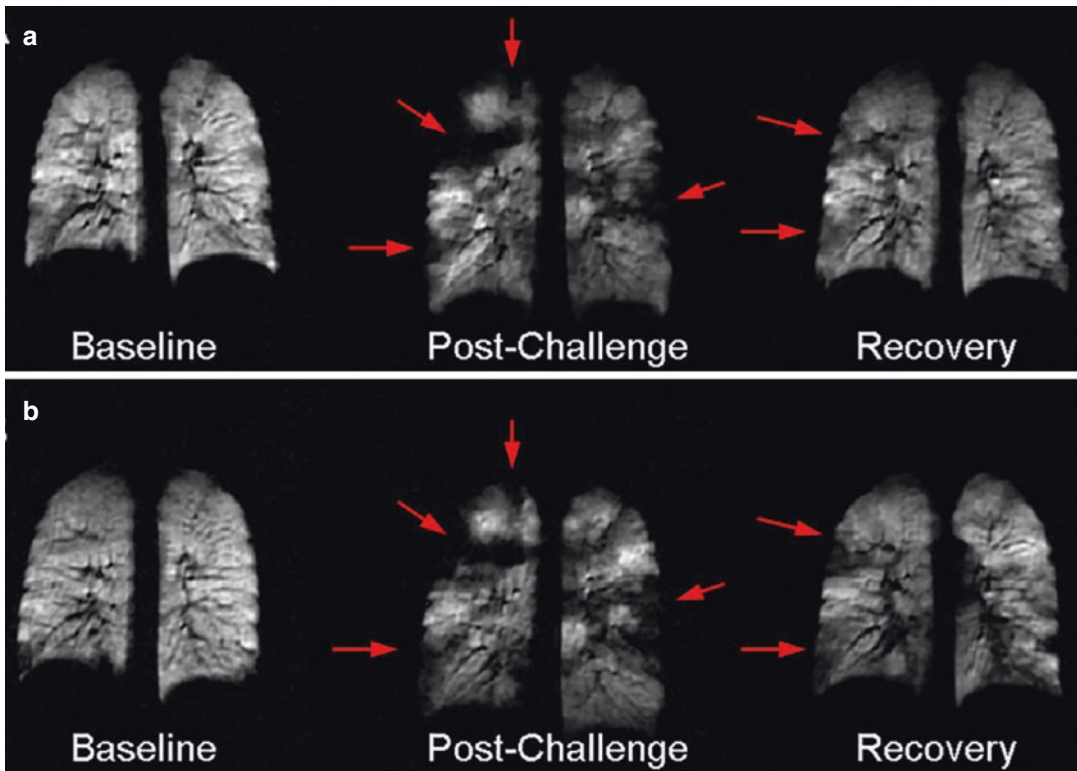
Repeated HP ^3He MRI in exercise-induced asthma showing two separate visits 1 week apart in the same patient in rows A and B. Columns correspond to pre-challenge (baseline), 10 min. after exercise challenge
